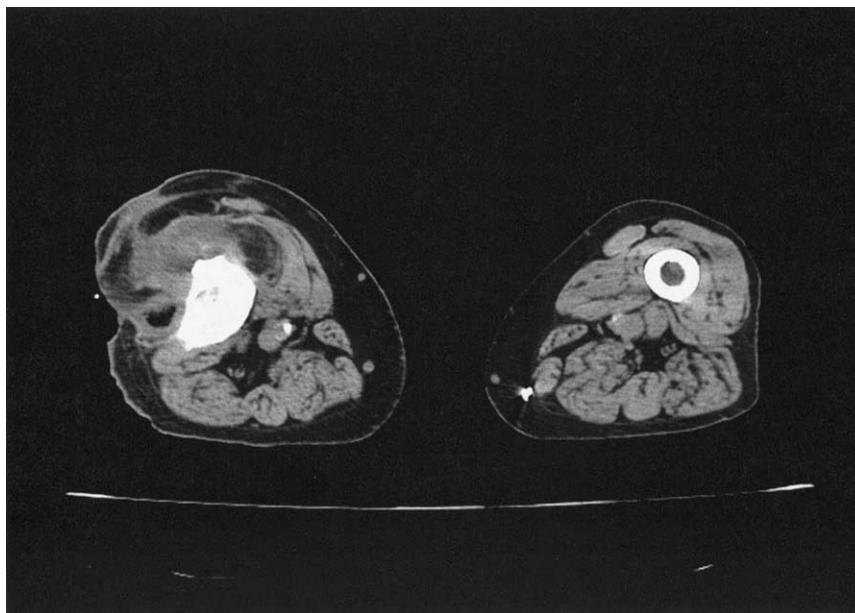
Computed tomography of a femur with signs of sequestrum. Note thickened cortex and destruction of the normal intramedullary cavity in the right femur. Soft tissue changes anterior and lateral to the right femur are also apparent.
